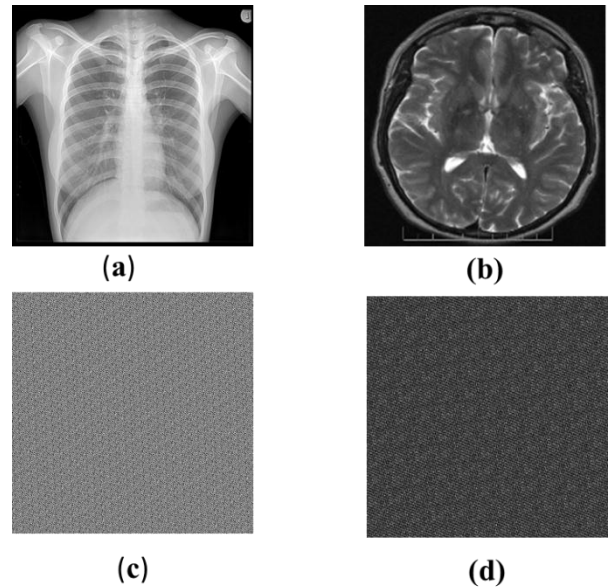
(a) Chest X-Ray, (b) Cross-Sectional Image of a human skull, (c) Arnold Transformed Chest X-Ray and (d) Arnold Transformed Cross-Sectional Image of a human skull.
